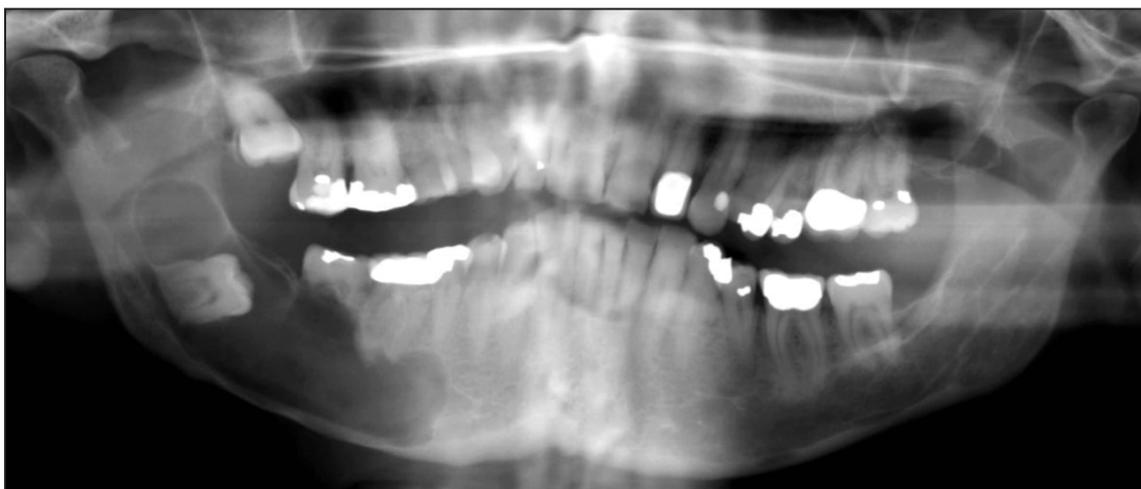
Orthopantomogram showing lesion in the mandible right side.
